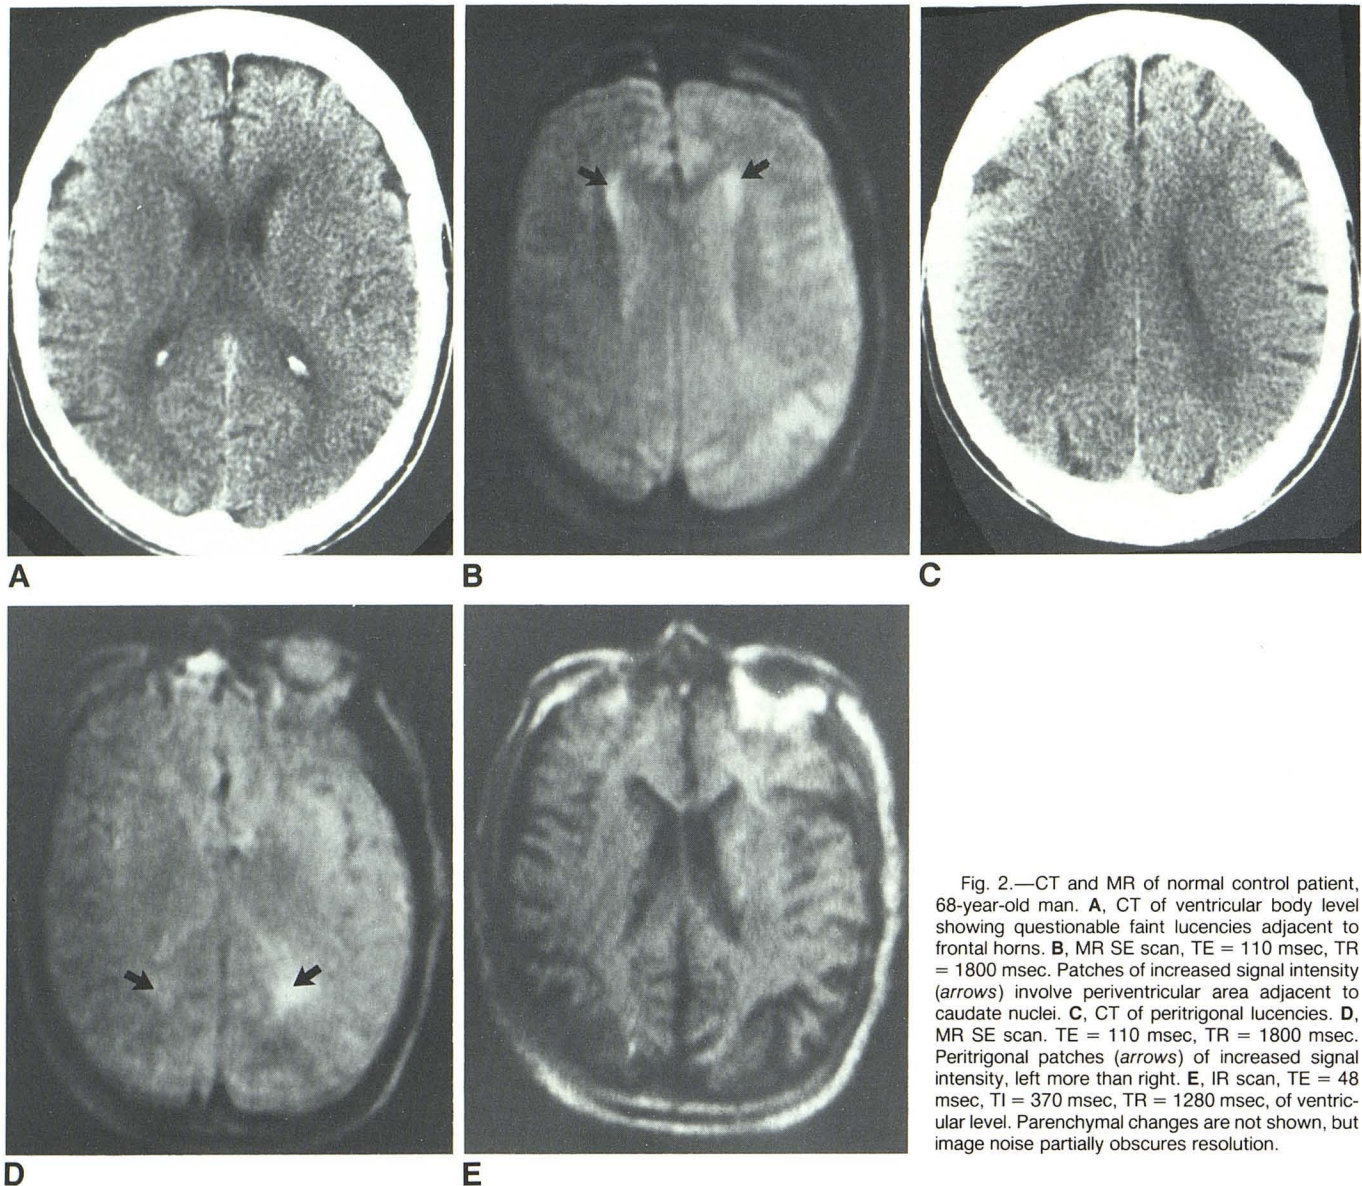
CT and MR of normal control patient, 68-year-old man. A, CT of ventricular body level showing questionable faint lucencies adjacent to frontal horns. B, MR SE scan, TE = 110 msec, TR = 1800 msec. Patches of increased signal intensity (arrows) involve periventricular area adjacent to caudate nuclei. C, CT of peritrigonal lucencies. D, MR SE scan. TE = 110 msec, TR = 1800 msec. Peritrigonal patches (arrows) of increased signal intensity, left more than right. E, IR scan, TE = 48 msec, TI = 370 msec, TR = 1280 msec, of ventricular level. Parenchymal changes are not shown, but image noise partially obscures resolution.
